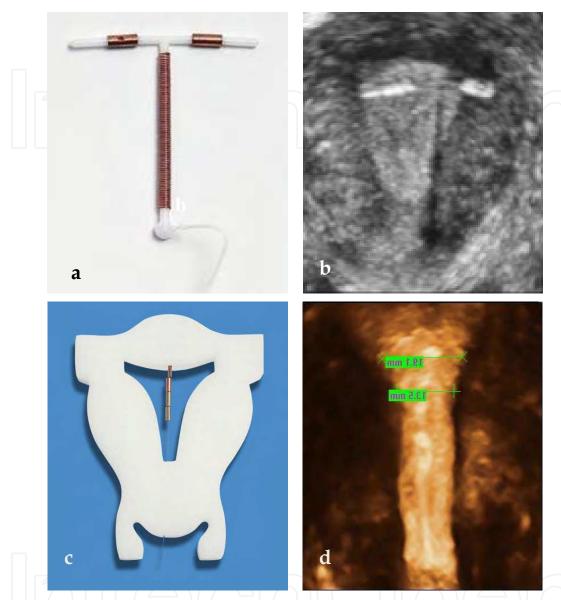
a) Paragard® IUD; b) 3-D sonography of Paragard® in small uterine cavity of which the left arm penetrates the uterine wall (courtesy of Dr. B. Benacerraf); frameless GyneFix® IUD in foam uterus; 3-D sonographic picture of GyneFix® in narrow uterine cavity (courtesy of Dr. S. Jandi).
